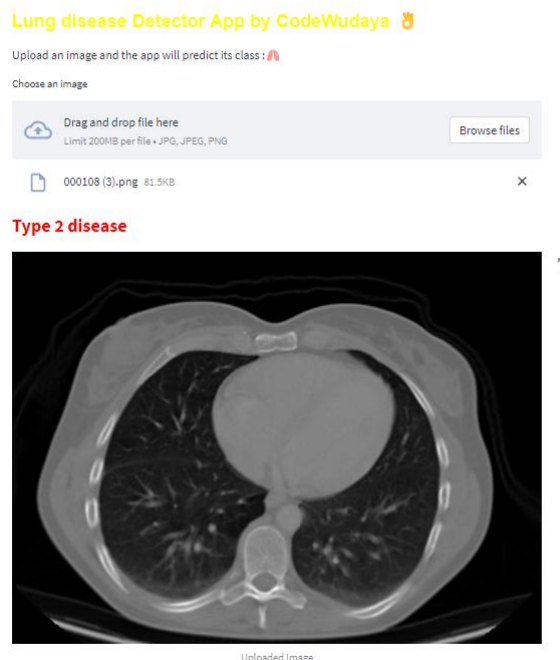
Screenshot of the Lung Infection Detection App showing CT image upload and “Type 2 disease” prediction.
